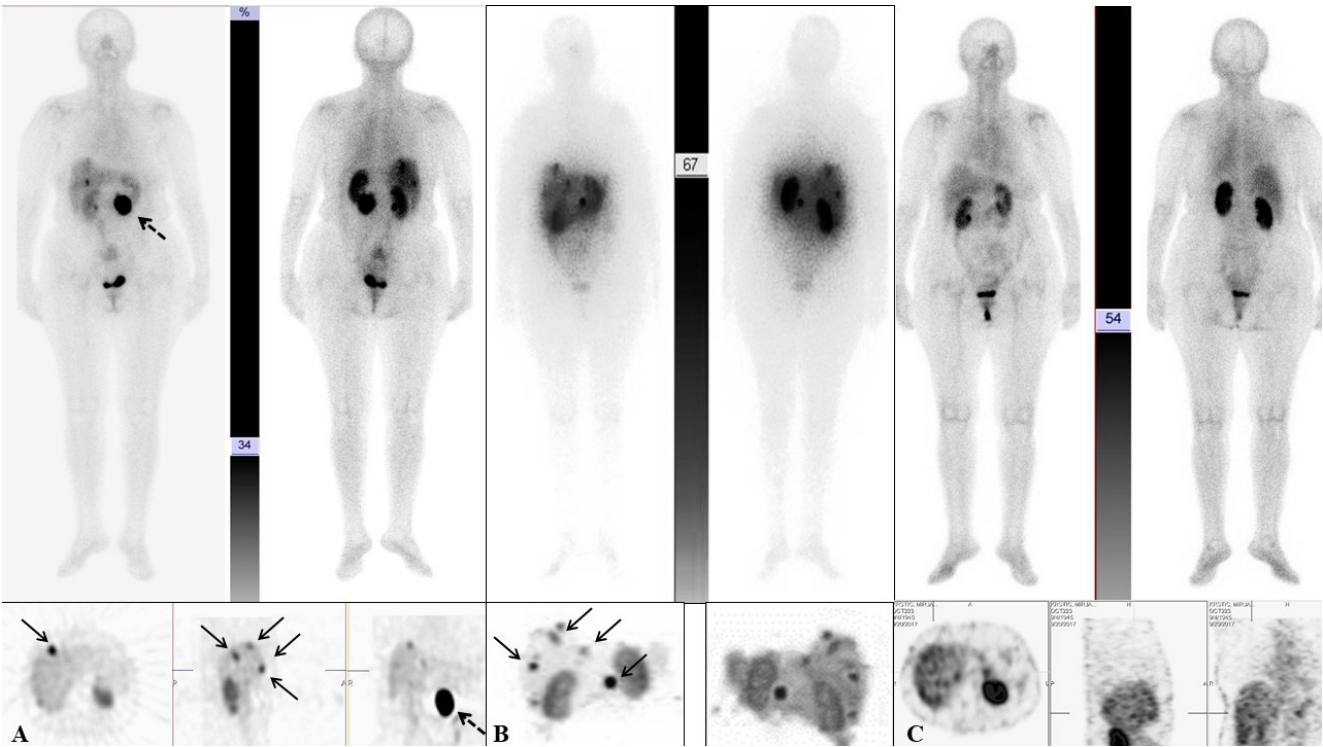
Whole body diagnostic scan and SPECT in patient with insulinoma (dotted arrow) and liver metastases (solid arrow)-NEN G2. A: Diagnostic scan with ^{99m}Tc-Tektrotyd clearly delineating the primary lesion and numerous metastases in the liver. B: Posttherapy scan with ¹⁷⁷Lu-DOTA-TATE after the surgery of primary tumor and first PRRT demonstrate multiple liver lesions. C: Control ^{99m}Tc-Tektrotyd scan following PRRT shows complete resolution of all liver lesions.
